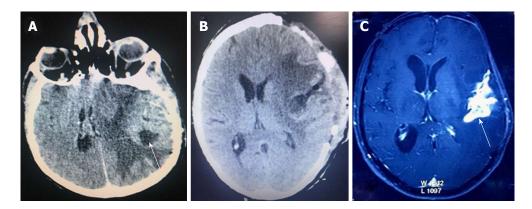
Showing radiological scans and findings. A: Computed tomography (CT) scan at initial diagnosis suggestive of glioma; B: Post-operative image of CT scan with adequate tumor excision and reduced mass effect; C: Magnetic resonance image after 18 mo showing the progressive recurrence of tumor.
